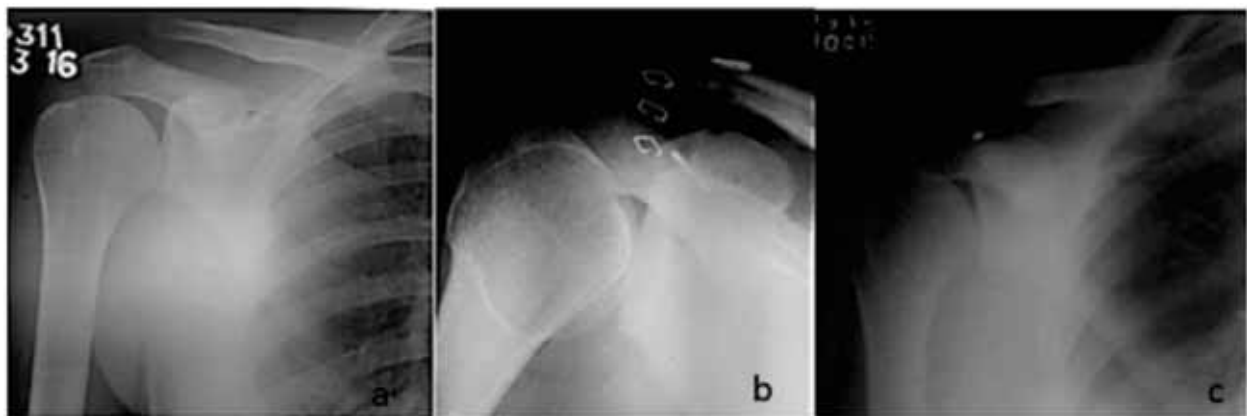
(a-c): Radiographs of ACJ: pre-operative (3a), post-operative (3b), implant failure at 6 months (3c)
